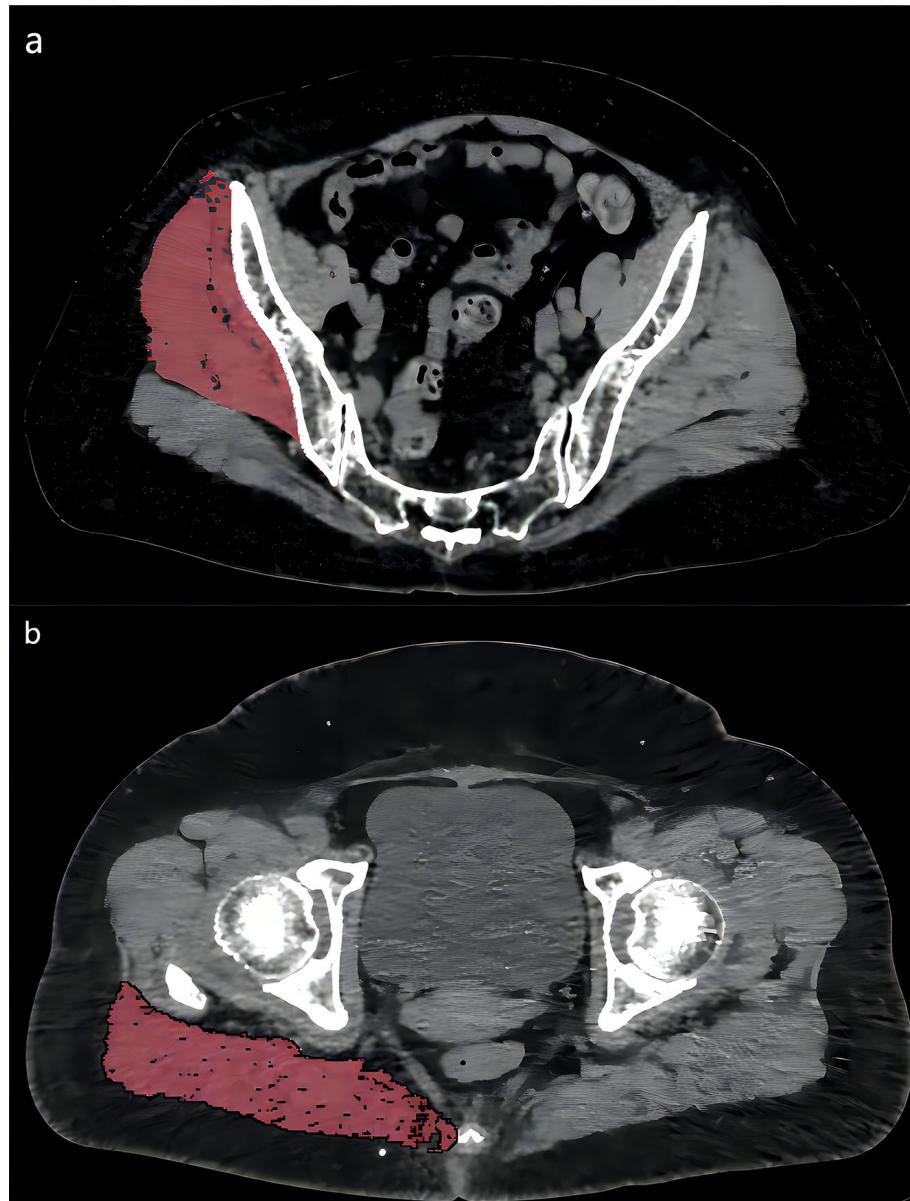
2a: Measurement of the gluteus medius and minimus muscles at the 3rd sacral (S3) level. 2b: Measurement of cross-sectional area and mean CT values of the gluteus maximus at the level of the greater trochanter of the femur. Muscle regions are highlighted in red.
